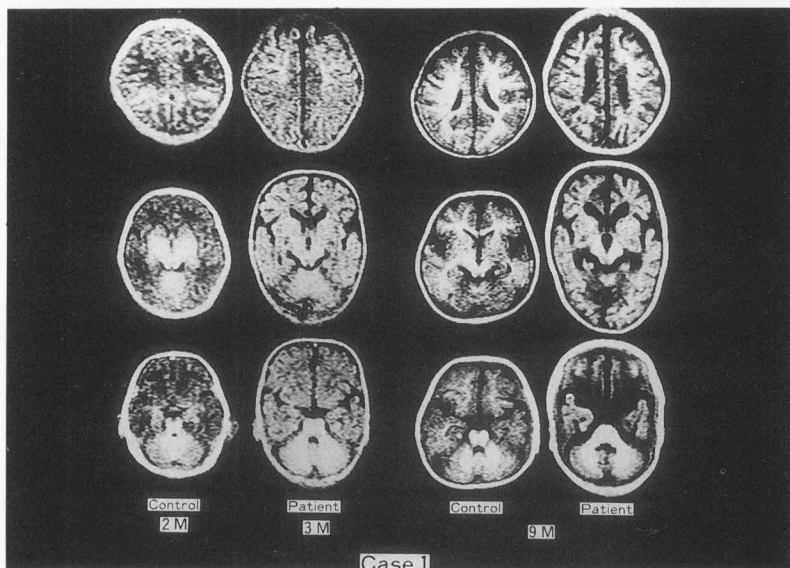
MRI on IR (2100/500) scans in case 1 disclosed little high signal areas in white matter and basal ganglia at three month old (Left), and poor high signal areas in white matter with brain atrophy at nine months old (Right).
